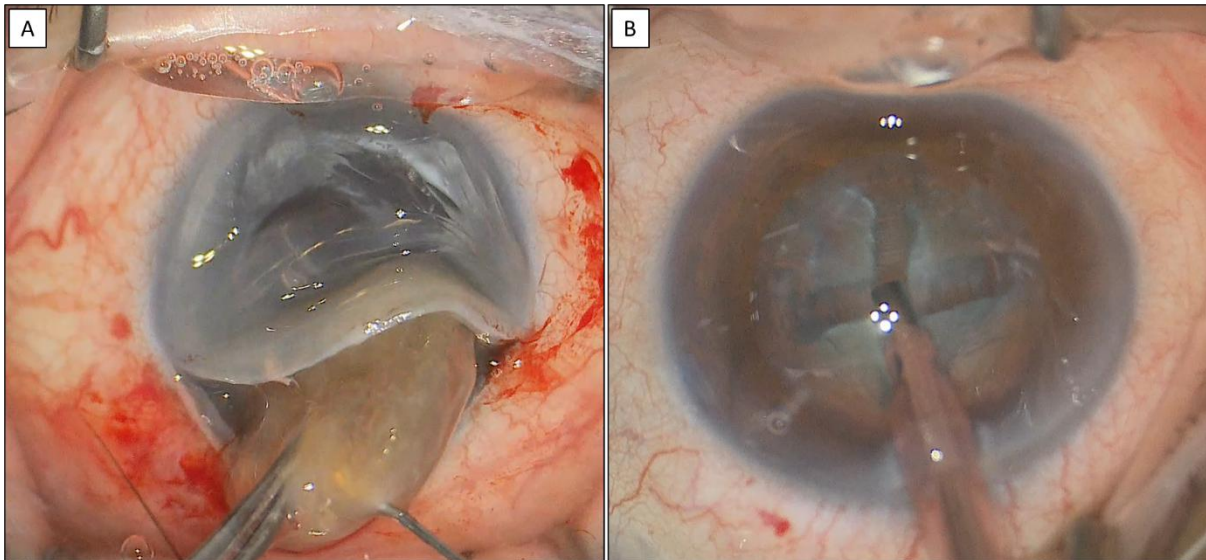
A) Historical technique of manual extraction of the entire lens through a large corneal incision B) Current technique of extraction by intraocular fragmentation of the lens using ultrasound through a small 2.2 mm corneal incision
